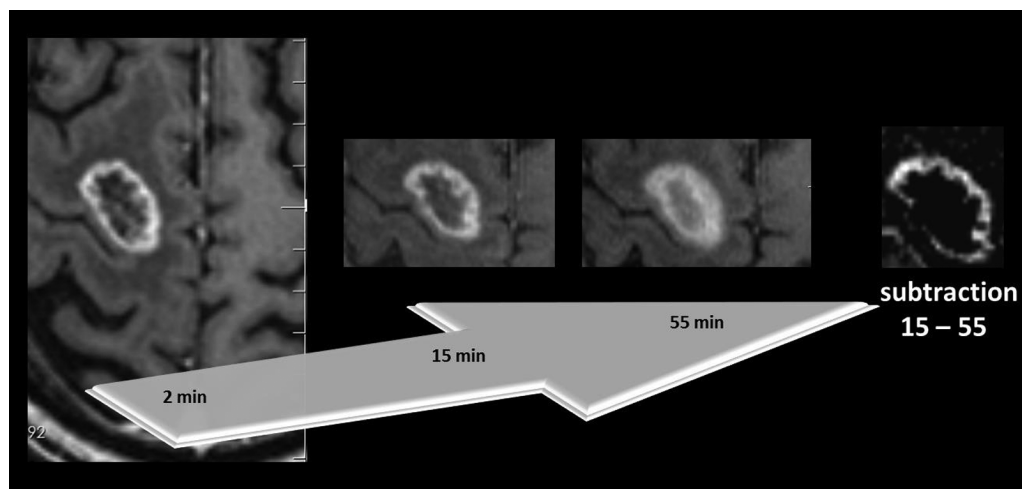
Radiation-induced necrosis in a 49-year-old woman with SRS-treated brain metastasis from lung cancer. Axial T1-weighted MR images 2min, 15min, and 55min after contrast agent administration with subtraction image 15min minus 55min. A homogeneous black inner area of the lesion is seen in the subtraction image without any white components. Progressive “fill in” up to 55min is seen with increasing SI in the inner area.
